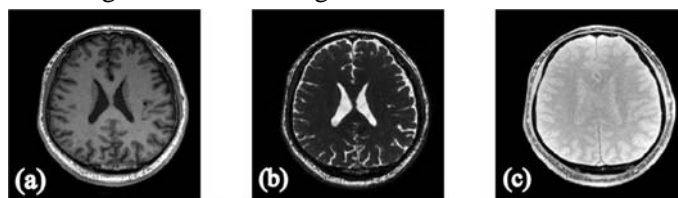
A slice of MR images acquired with (a) T1-weighted, (b) FSPDW and (c) FIESTA.
